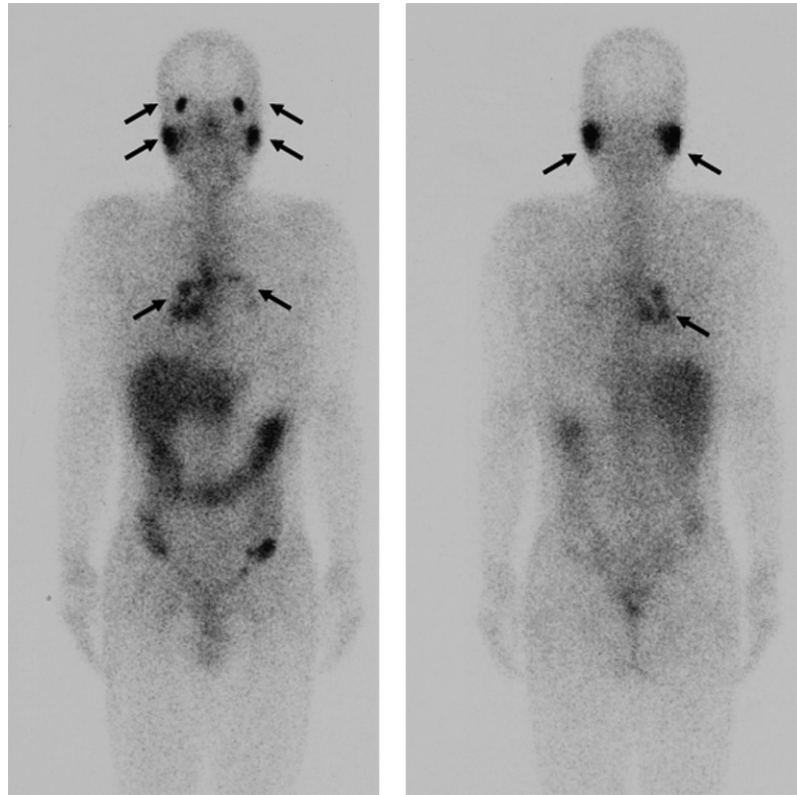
$^{67}\text{Ga}$  scintigraphy showing bilateral abnormal accumulation in lacrimal glands, parotid glands and hilar lymph nodes (arrows).
